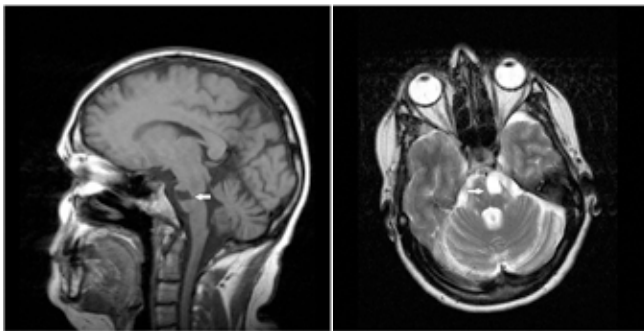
T1-weighted sagittal and T2-weighted axial MRI brain demonstrating an extensive left pontine gliotic scar (May 2009).
